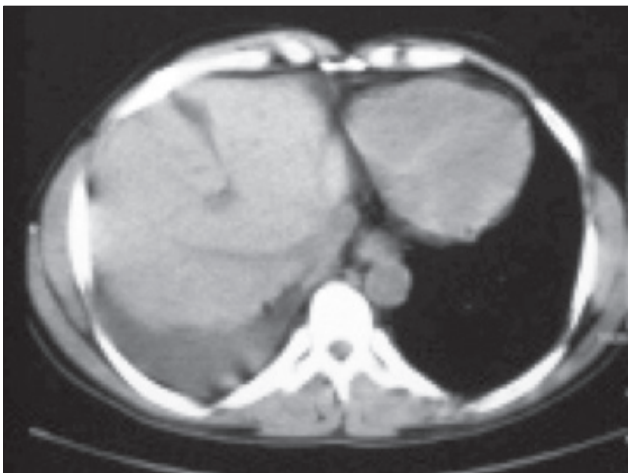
Computed tomogram showing discontinuity of the right hemidiaphragm, minimal liver laceration and presence of the liver in the paracardiac region.
